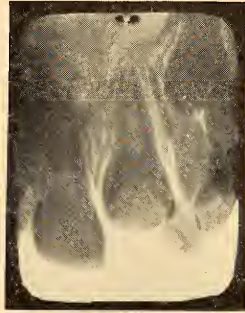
Radiograph showing the delayed eruption of a central incisor.
